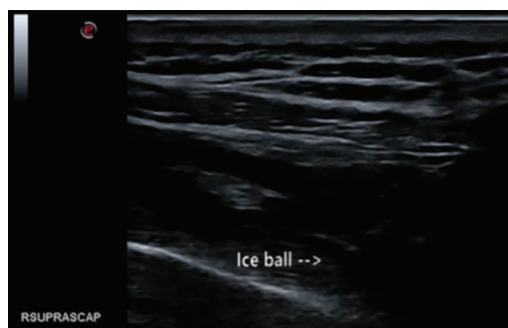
Ultrasound images of the ice ball formed at the suprascapular notch
